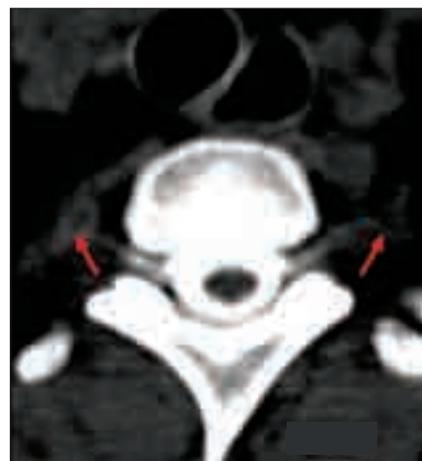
Computed tomography myelogram. Note extradural leakage of contrast (arrows).
